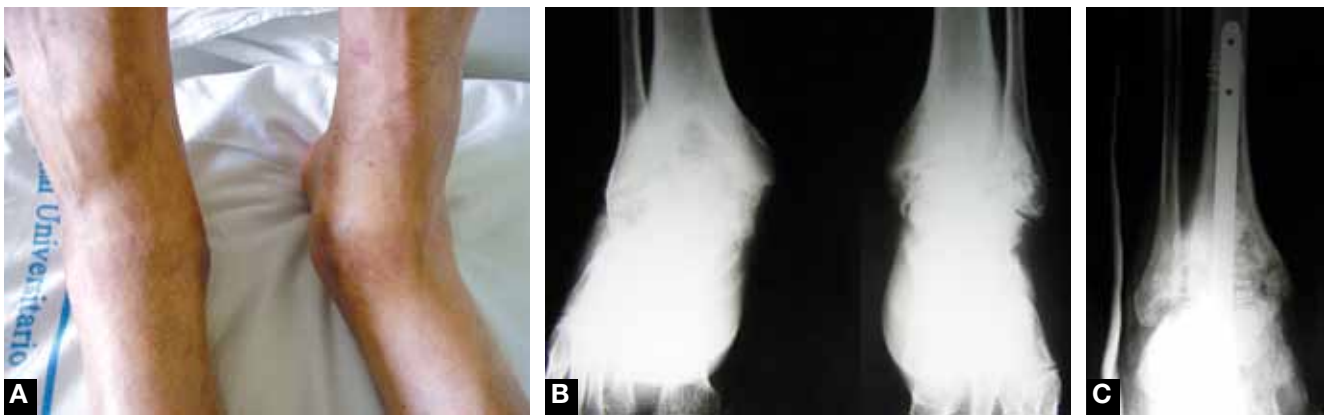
Patient with inhibitor underwent right ankle arthrodesis with locked retrograde intramedullary nail. (A) Preoperative clinical view shows severe arthropathy. (B) Radiographs confirm intense hemophilic arthropathy of ankles (more severe in right ankle). (C) Postoperative anteroposterior view shows satisfactory result.
